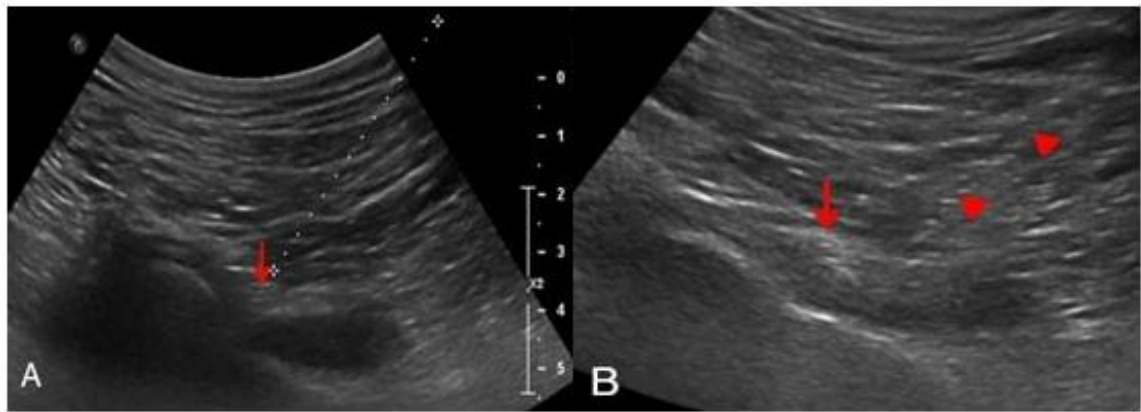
Before (A) and during (B) left sciatic nerve hydrodissection under ultrasound guidance. Ultrasound guided nerve hydrodissection was performed using dexamethasone (1ml) and 5% dextrose water (5cc) around the left sciatic nerve (arrow) beneath piriformis muscle. Needle (arrow heads).
